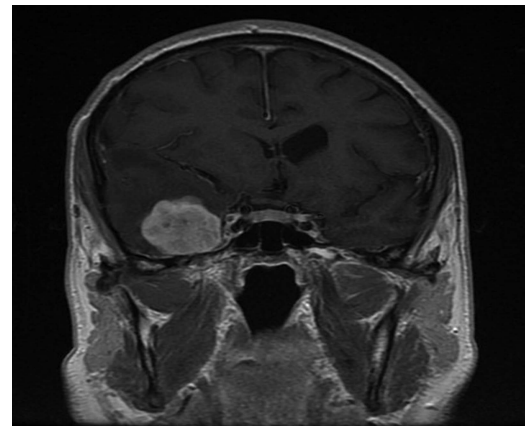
MRI at presentation.
